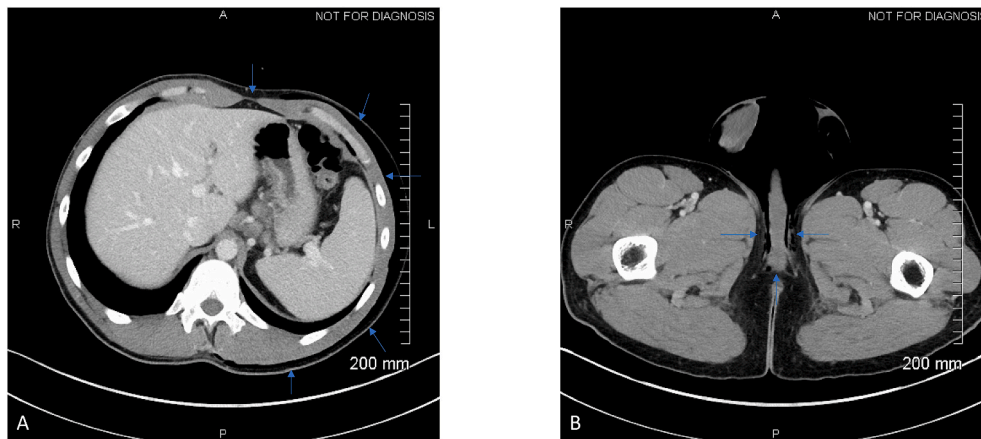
1A CT with contrast demonstrates extensive subcutaneous emphysema within the left abdominal wall. 1B CT with contrast demonstrates extensive subcutaneous emphysema within the scrotum.
